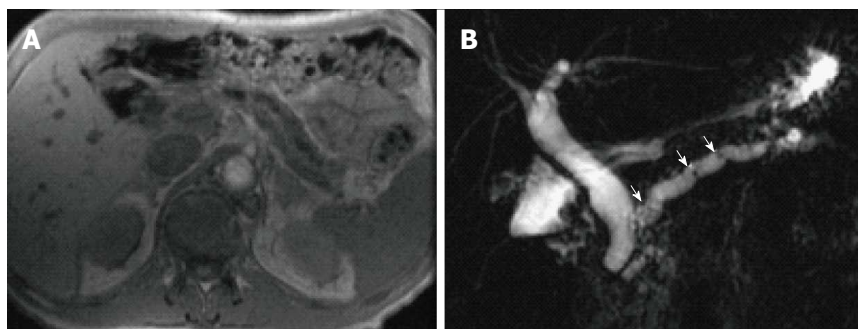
Chronic pancreatitis. A: Axial T1-weighted GRE MRI. B: Coronal-oblique thick-slab MRCP image. There is evidence of diffuse thinning of the pancreatic parenchyma with uniform dilatation of the pancreatic duct and prominence of the pancreatic duct side-branches (A-B), associated with multiple tiny stones at the proximal pancreatic duct (arrows, B) in keeping with chronic pancreatitis. There is also mild uniform dilatation of the CBD, which tapers down to the level of the pancreatic duct (B).
